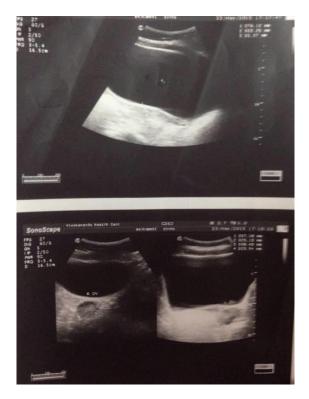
Ultrasonography showing bilateral polycystic ovaries, Right measuring: 3.7 x 2.5 cm and Left measuring: 3.8 x 2.4 cm bilateral multiple peripheral follicles noted with e/o multiple interphases.
